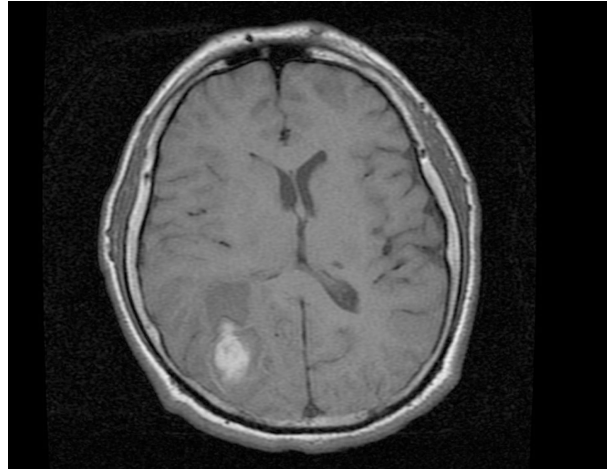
MRI of the brain, T1-weighted image, showed a right parietal hematoma with vasogenic edema and mass effect on the lateral ventricle.
